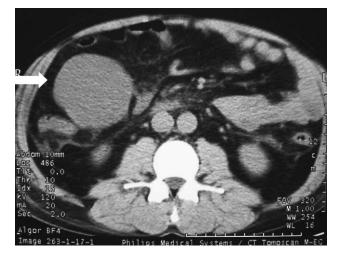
Abdominal computed tomographic scan showing a well-circumscribed, homogeneous mass of low attenuation, located in the iliac area (*arrow*).
